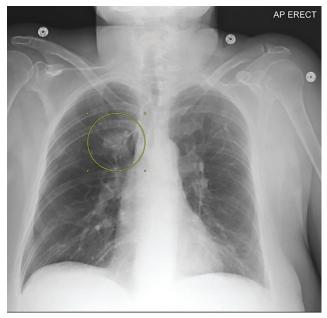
Chest radiograph on admission showing a new opacity superior to the right hilum (circle).
